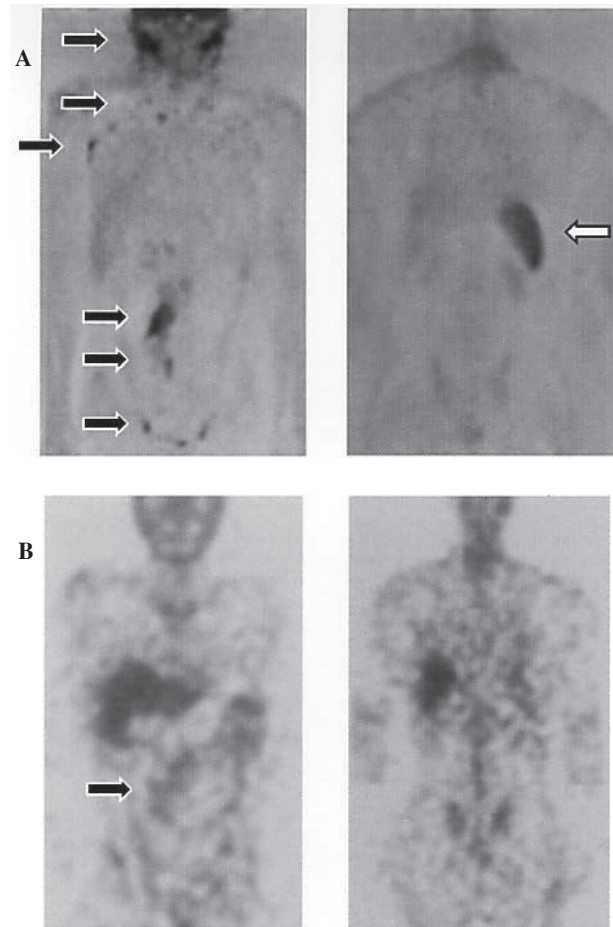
A 36-year-old man with Stage IV NHL (Patient 18). ^{18}F -FDG PET images reveal intense accumulation of ^{18}F -FDG in the neck, subclavia, axilla, para-aorta, mesentery, inguena (black arrow), and spleen (white arrow) (A). ^{67}Ga SPECT images only show accumulation of ^{67}Ga in the para-aorta (black arrow) (B). This case was understaged by ^{67}Ga SPECT compared with ^{18}F -FDG PET (Stage I to IV).
